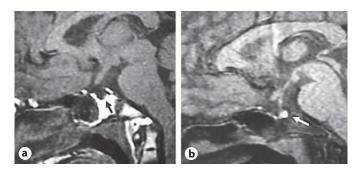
MRI of the brain, sagittal T_1 -weighted (a) and with fat suppression (b), showing hypoplasia of adenohypophysis (black arrow) of the pituitary gland, and intact stalk with normal posterior lobe (white arrow).
